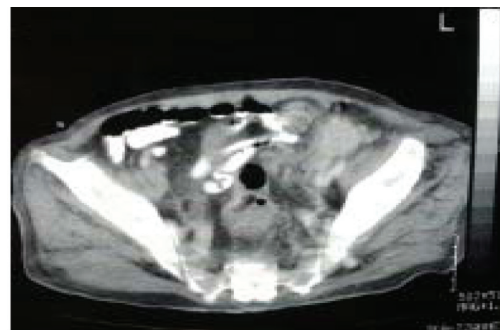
Computed tomography (CT) of the abdomen showed a 6 cm solid mass in the left groin.
